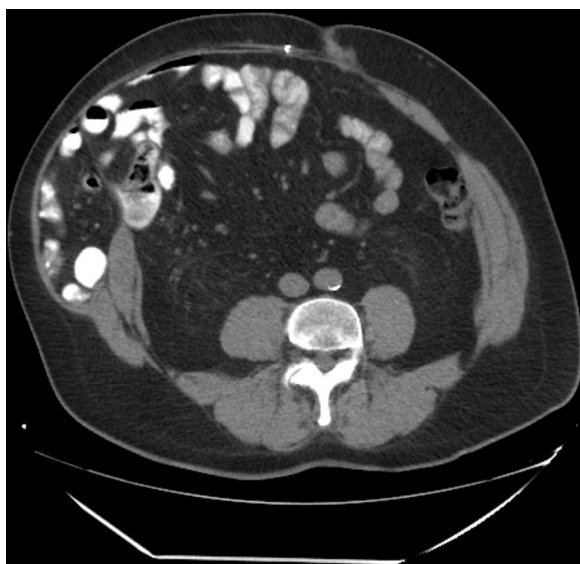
CT showing intraparietal hernia with disruption of the semilunar line.
